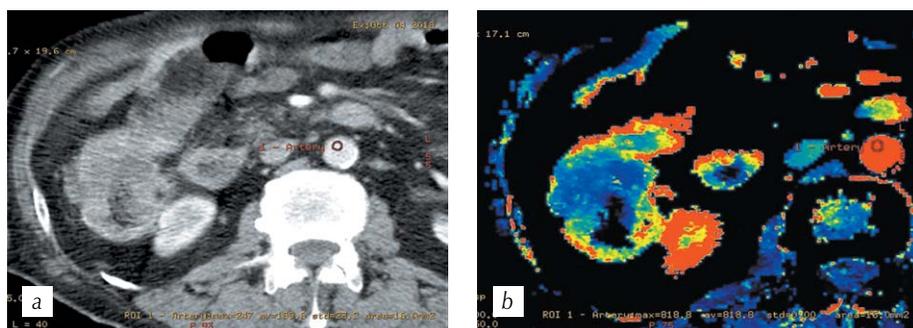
CT, multiplanar reconstruction in the axial plane in the arterial phase (*a*), with a thin dividing strip of adipose tissue between ascending colon tumor and the kidney capsule; *b* — CT perfusion, parametric map of the blood volume showing the invasion of the adipose tissue and the kidney capsule by the ascending colon tumor
